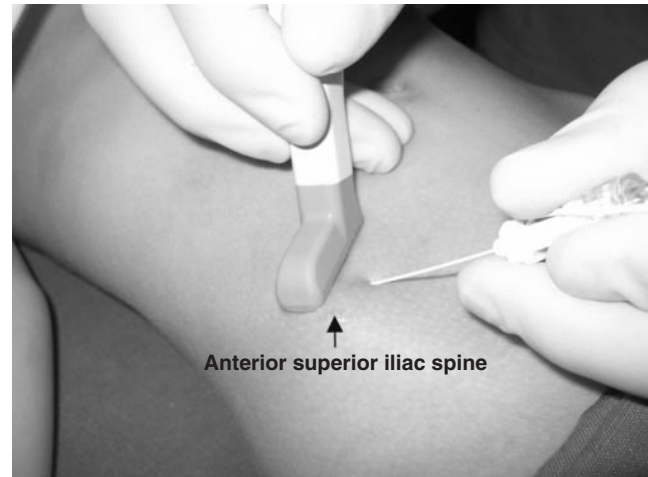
Position of the ultrasound probe relative to the cannula for an optimal view of the ilioinguinal/iliohypogastric nerves.
